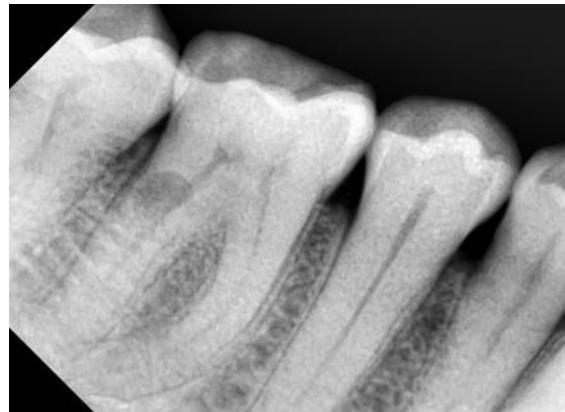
Pre-operative radiograph of 46 showing internal resorptive defect in the distal root canal
